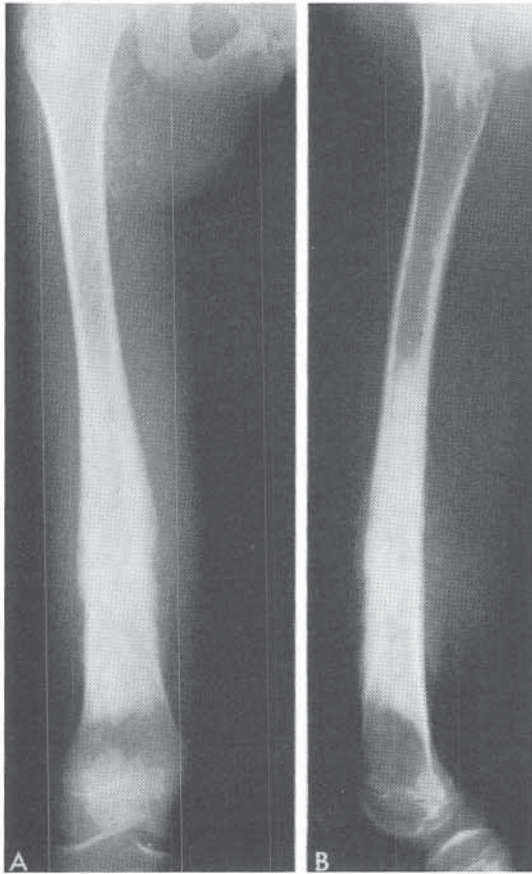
Osteogenic sarcoma of the distal femur in a 12-year-old girl. A and B, Radiographs of the femur. The normal trabecular pattern is lost as the neoplastic bone has invaded the cortex and has raised the periosteum. Note the “sunburst” appearance and Codman’s triangle. The conical plug of the tumor in the midshaft (best seen on the lateral view) marks the proximal limit of the lesion lengthwise along the shaft.
